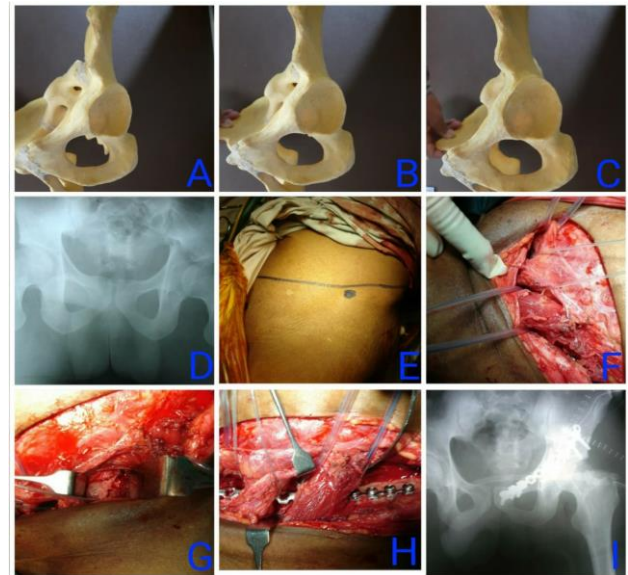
Acetabular fracture managed with IIA; (A-C) Accessed regions of IIA, (D) preoperative X-ray, (E) landmark for incision, (F) 3 windows seen during IIA; (G) intraoperative photograph of fracture site, (H) intraoperative photograph showing plate fixation, (i) postoperative X-ray.
